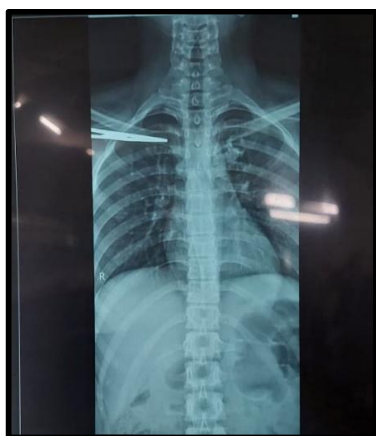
X-ray of chest (A-P view)
